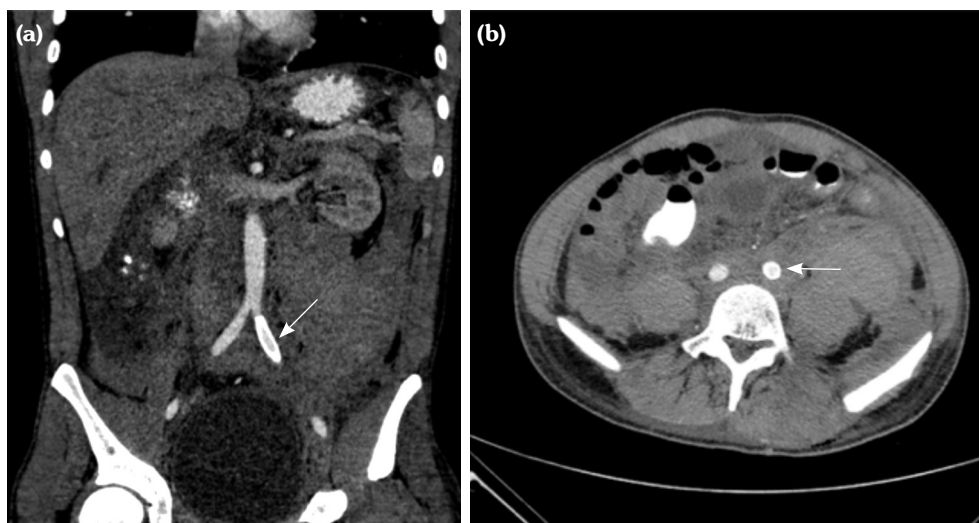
Postoperative third month control abdominal CT angiography. (a) Coronal. (b) Axial images.
